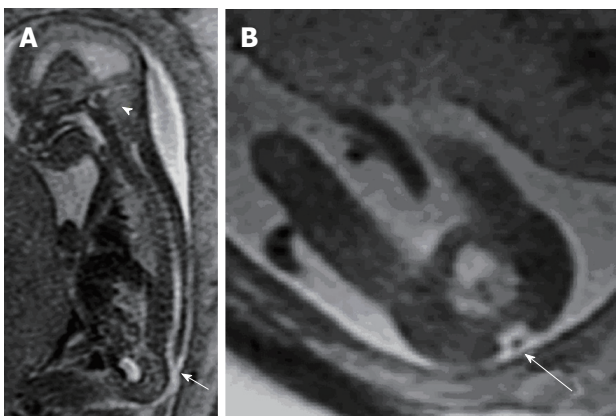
Fetal magnetic resonance imaging. A: Sagittal T2 weighted fetal MR demonstrates a small posterior fossa (arrowhead) with crowding of the cerebellar tonsils and hindbrain; B: Evaluation of the spine demonstrated a lumbosacral myelomeningocele.
